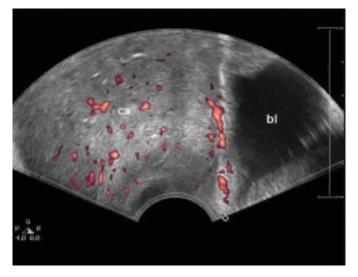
Transvaginal Doppler flow mapping showing the cervix is infiltrated by a hypervascular tumor. (cx = cervix; bl = bladder)
